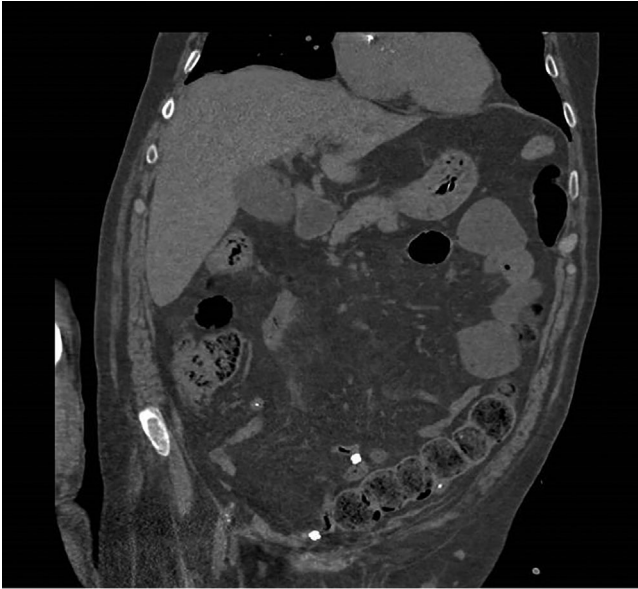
Abdominal computed tomography (CT) shows the complete improvement of the clinical picture
